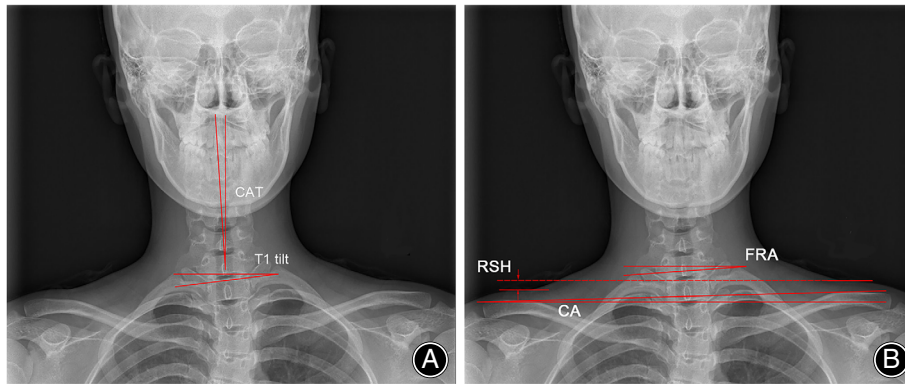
Radiographic parameters used to evaluate shoulder and neck imbalance. (A) CAT: angle between the cervical axis (line connecting center of odontoid process and center of C7 vertebra) and the vertical axis. T1 tilt: angle between the upper end-plate of T1 vertebra and the horizontal line. (B) FRA: angle between the tangent line of superior margin of first rib and the horizontal line. CA: angle between the line connecting the highest point of the left and right clavicle and the horizontal line. RSH: Vertical distance between superior horizontal reference line (SHRL) and inferior horizontal reference line (IHRL)
